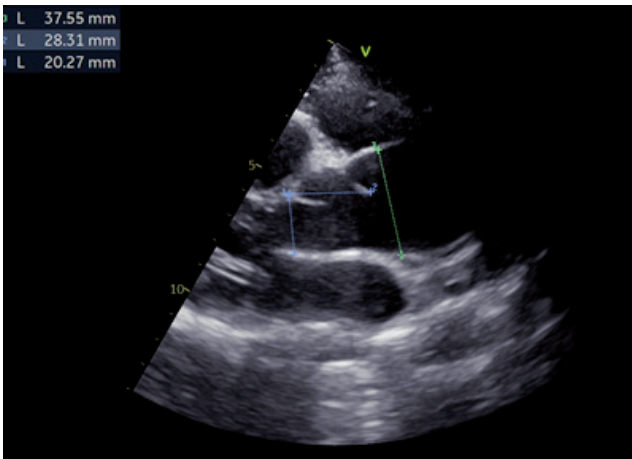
Parasternal long axis view dilation of ascending aorta Z +5.3
